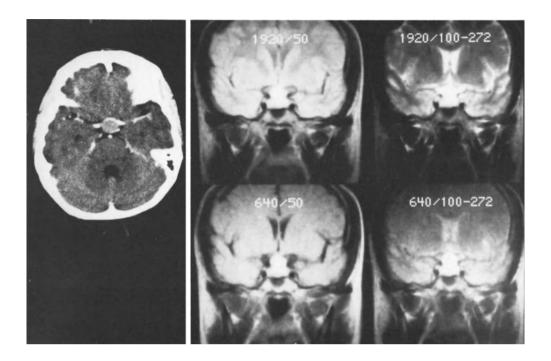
Fifty-year-old female patient with moderate hyperprolactinemia (prolactin) in the serum: 49 ng/ml). A space-occupying lesion appearing to be a solid tumor on contrast-enhanced CT (left) and MRT with different TR/TE parameters (right) proved intraoperatively to be a cysticercotic cyst
